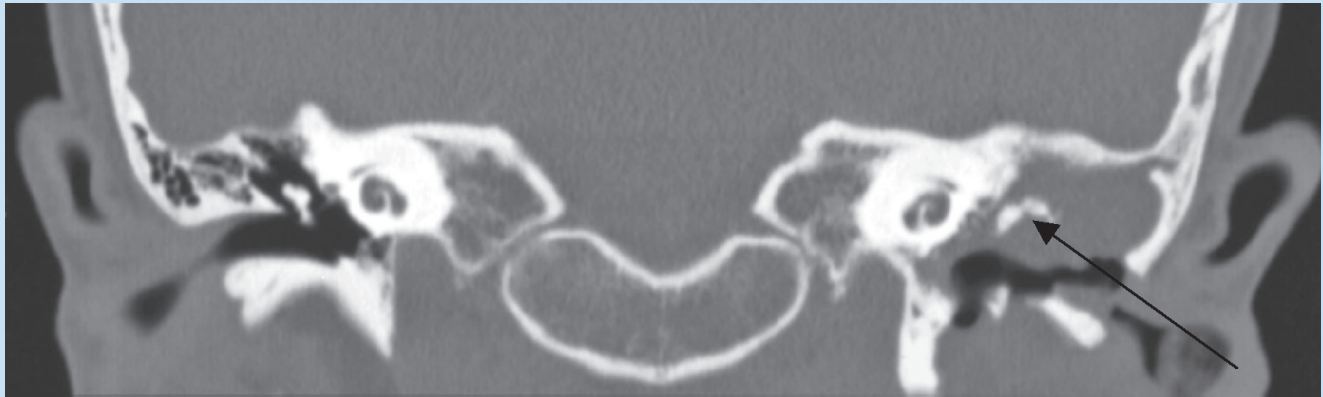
Coronal CT with bony windows showing the invasive cholesteatoma eroding and displacing the incudo-malleolar complex (arrow).
